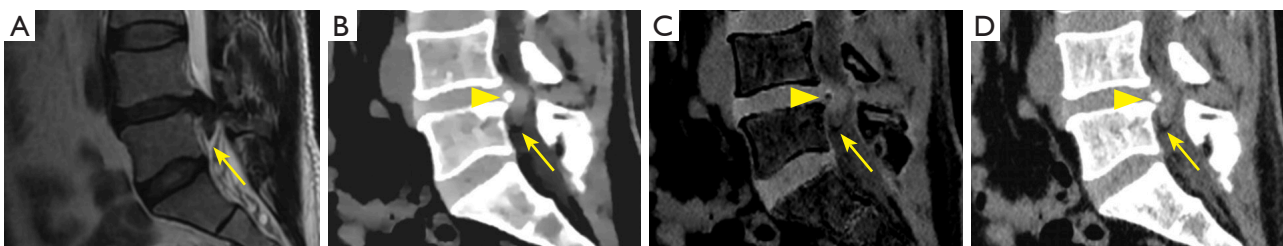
A 41-year-old male with the chief complaint of low back pain with radiating pain in his left leg. (A) Sagittal T2-weighted image showing lumbar disc extrusion at the L4/L5 level [yellow arrows in (A-D)]. (B) ED image providing clearer visualization compared to (C) VNCa and (D) SC. Disc calcification [yellow arrowheads in (B-D)] visible on ED and SC images but subtracted and appearing black on the VNCa image, thus being indistinguishable on sagittal T2-weighted imaging. ED, electron-density; VNCa, virtual noncalcium; SC, standard computed tomography.
